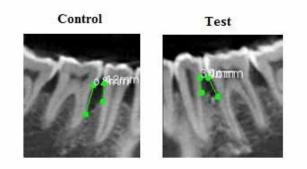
Radiographic evaluation of Periodontal Defect
